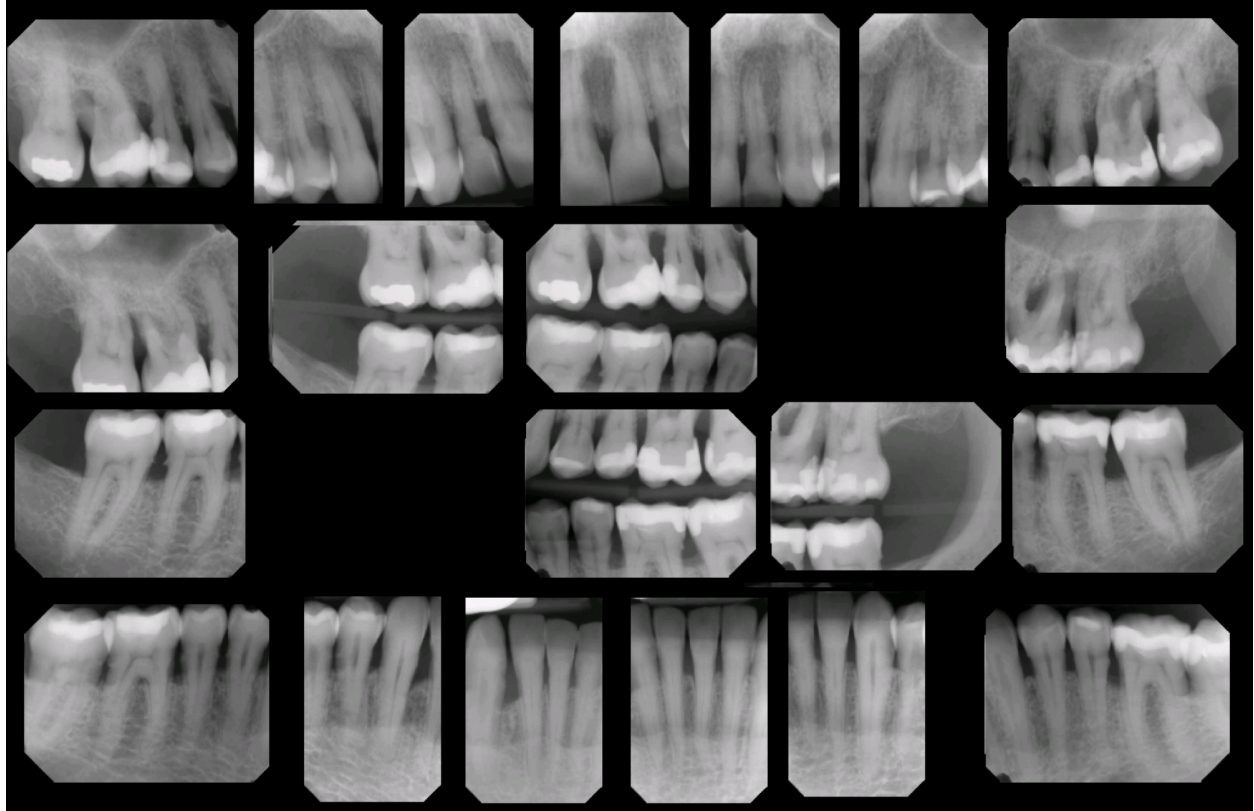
Full mouth radiographs corresponding to clinical case in Figures 1a-c
